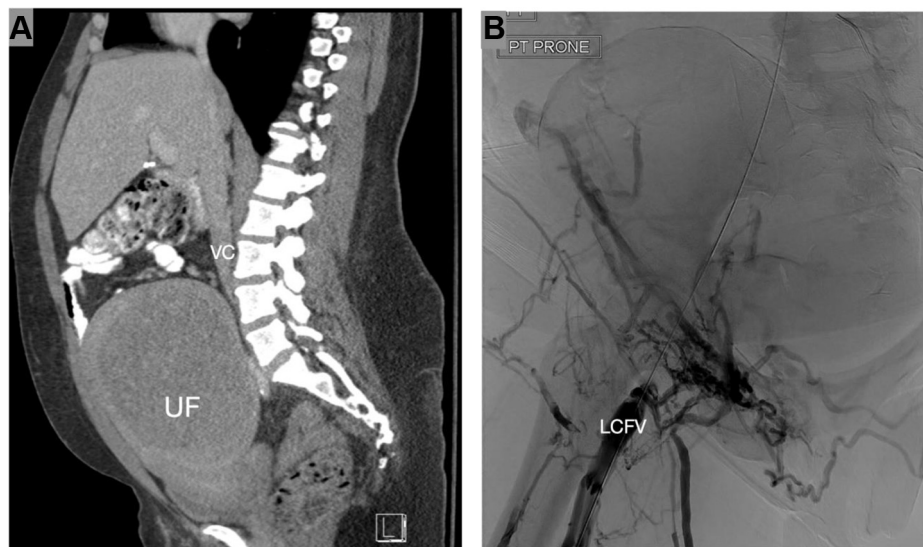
(A) Preoperative computed tomography single view sagittal cut demonstrating large fibroid uterus (UF) with compression of the inferior vena cava (IVC). (B) Preintervention intraoperative venogram demonstrating lack of opacification of the ilio caval venous system suggestive of thrombosis with termination of contrast in the left common femoral vein (LCFV).
